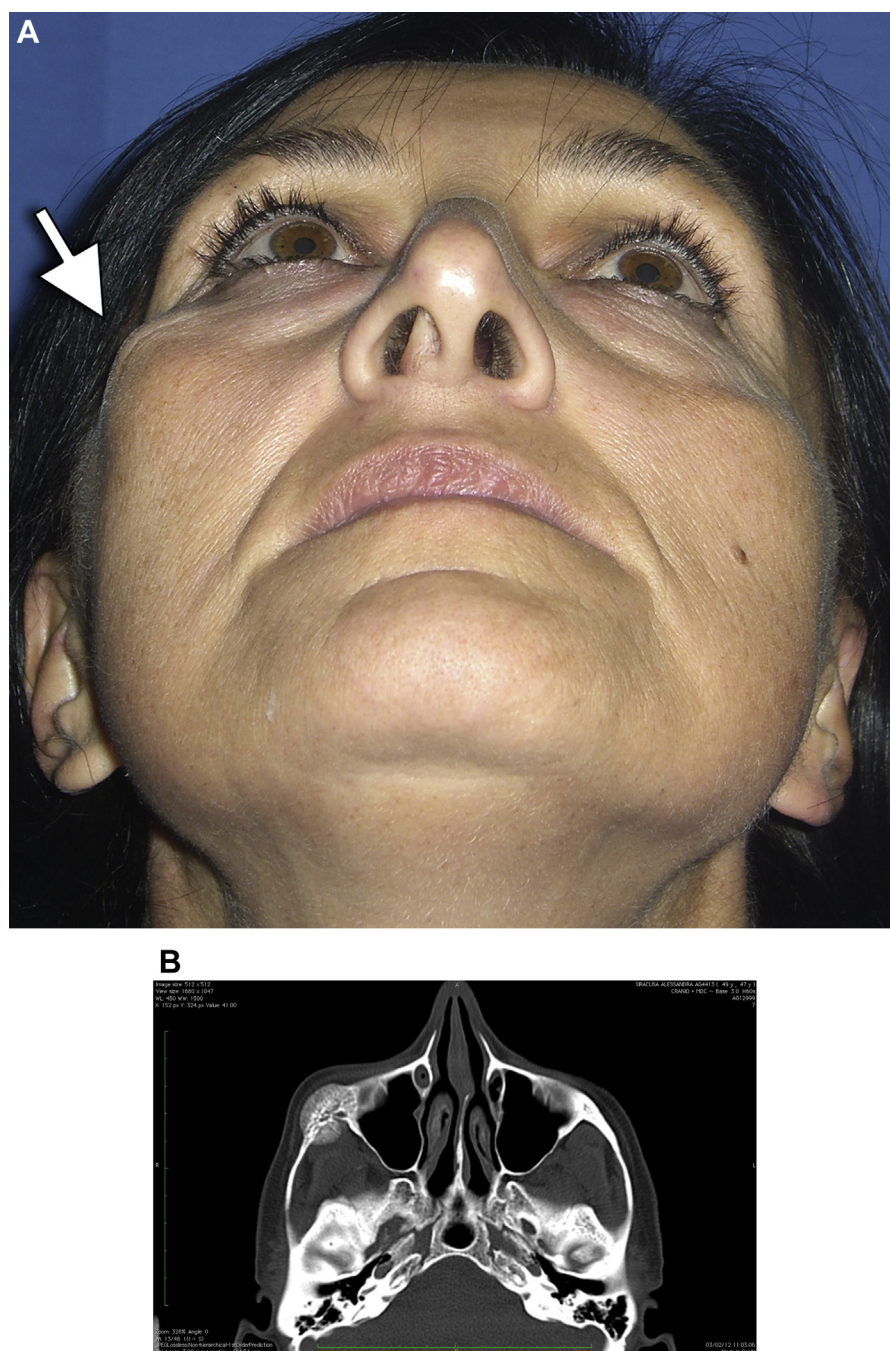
A 47-year-old woman presented with A, a long-lasting, painless, slow-growing right malar mass producing gross bone deformity (arrowhead). B, Computed tomography image showing a lesion with a “sunburst” pattern of the right malar bone that extended to the orbital floor and lateral wall. The clinical history and pathognomonic radiologic features were suggestive of an intraosseous venous malformation. (Fig 1 continued on next page.)
